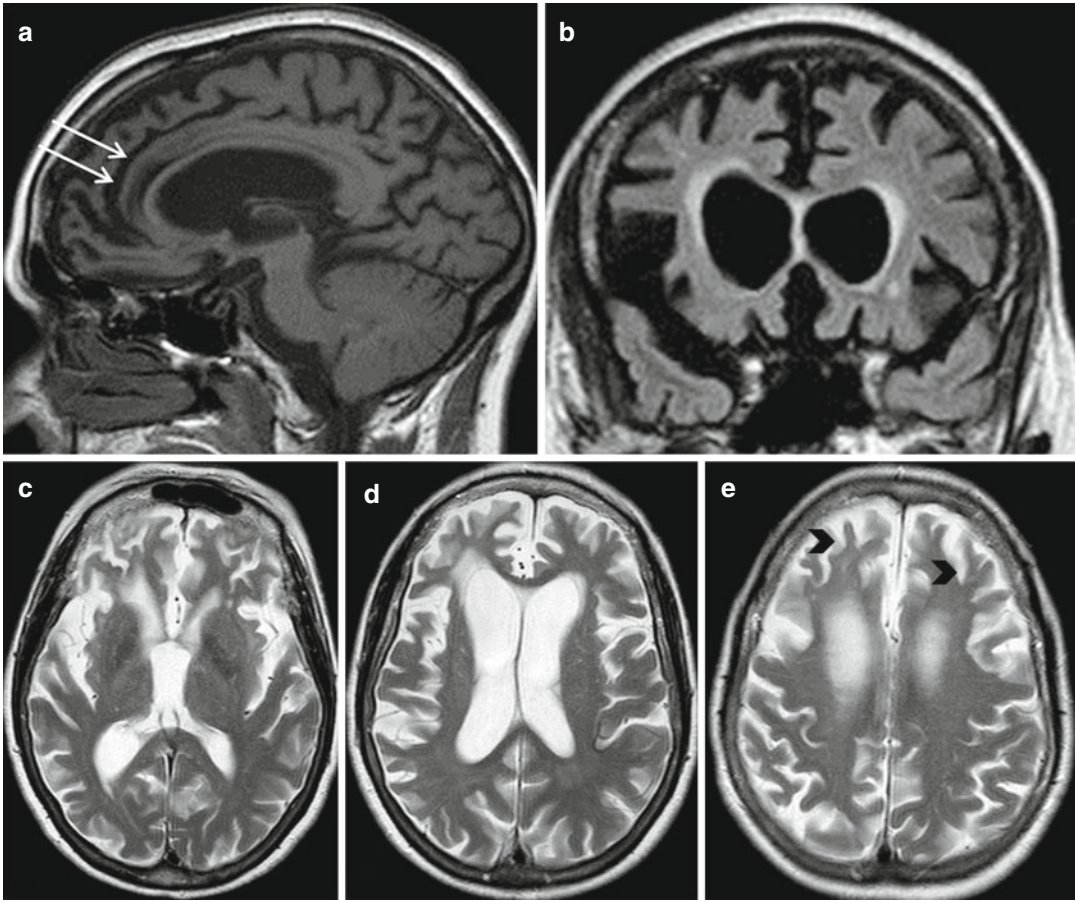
Fronto-temporal dementia (FTD), frontal variant. Sagittal T1-weighted image (a) shows frontal cortical atrophy with marked thinning of the anterior portion of the cingular gyrus (arrows). Coronal FLAIR and axial T2-weighted images (b–e) demonstrate diffuse cerebral atrophy, mainly in the frontal lobes and in the insular
